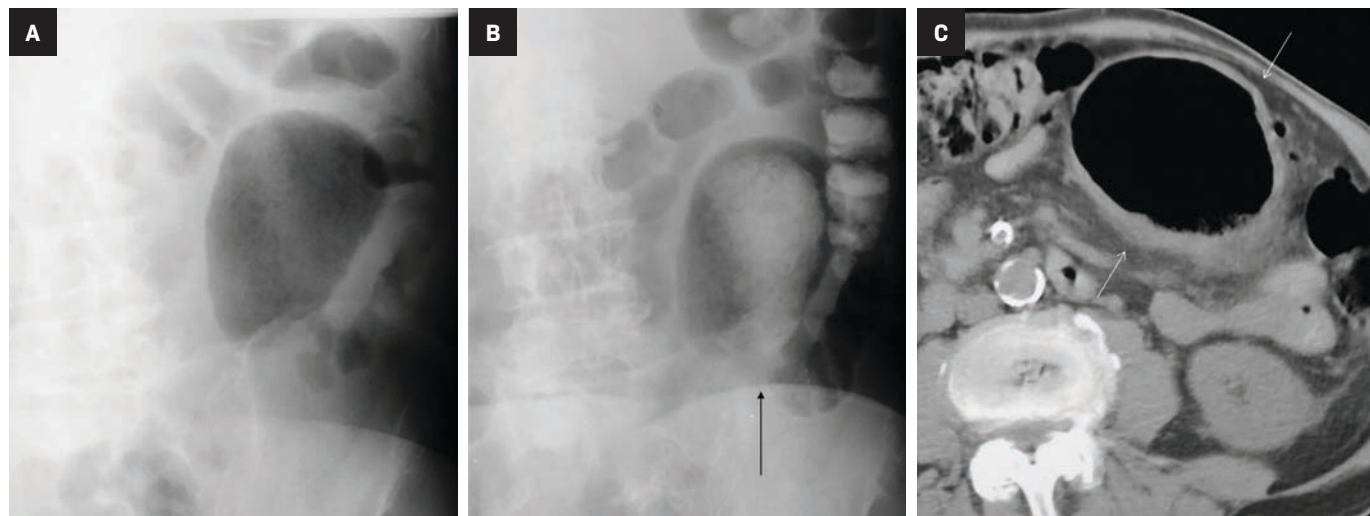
(A,B) CT of the abdomen in an elderly adult demonstrates the GSD as a gas-filled cavity with thick walls, associated with sigmoid diverticulitis.
